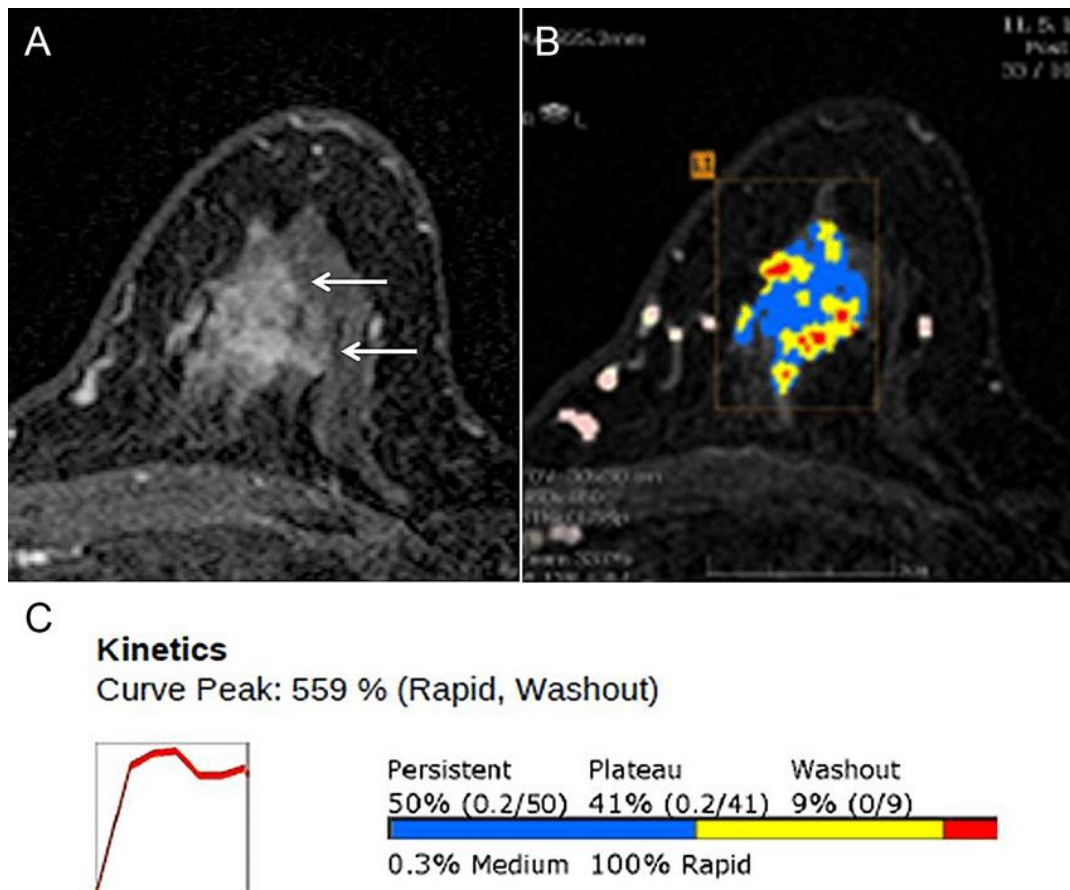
An example of MR images with computer-aided detection (CAD) showing an invasive ductal carcinoma in the left breast. (A) Axial T1-weighted MR image shows a 26-mm irregular mass (arrows). (B) Axial maximum-intensity-projection MR image shows CAD colour overlay over the breast mass. Areas in red, yellow, and blue indicate a rapid washout-type delayed enhancement, plateau-type delayed enhancement, and persistent-type delayed enhancement pattern, respectively. (C) Kinetic curve graph showing rapid initial enhancement and rapid washout-type curve.
